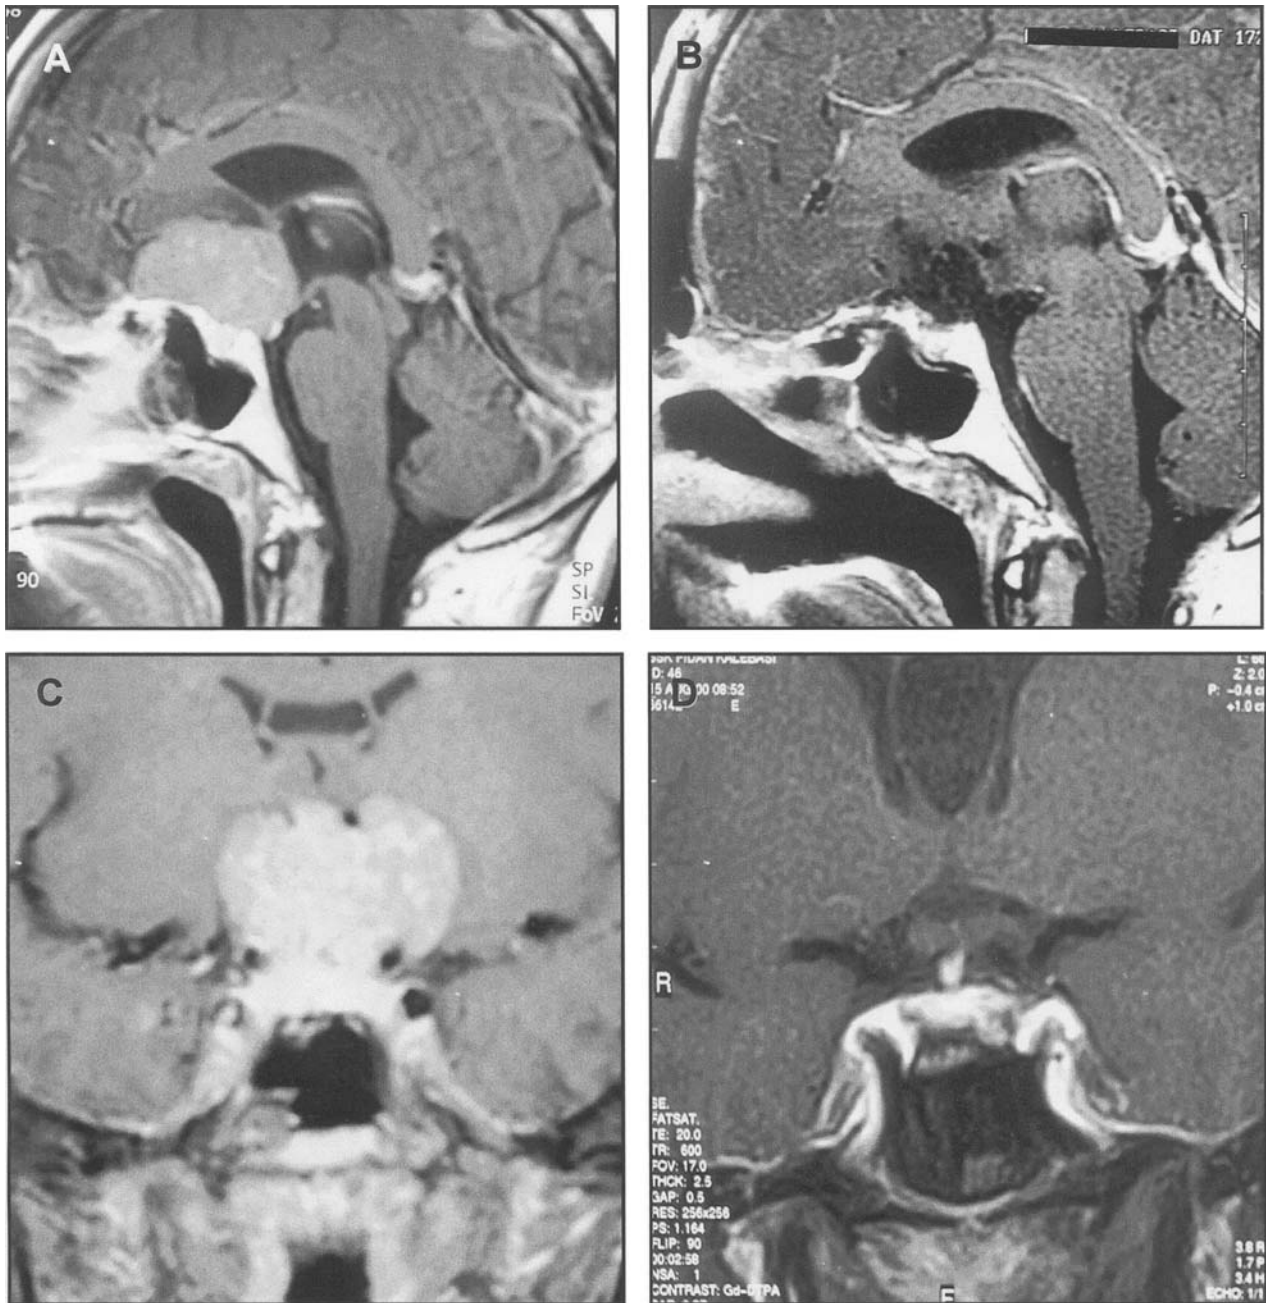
Pre (A and C) and postoperative (B and D) contrast enhanced MRI examinations of a tuberculum sellae meningioma showing total tumour removal after pterional craniotomy
